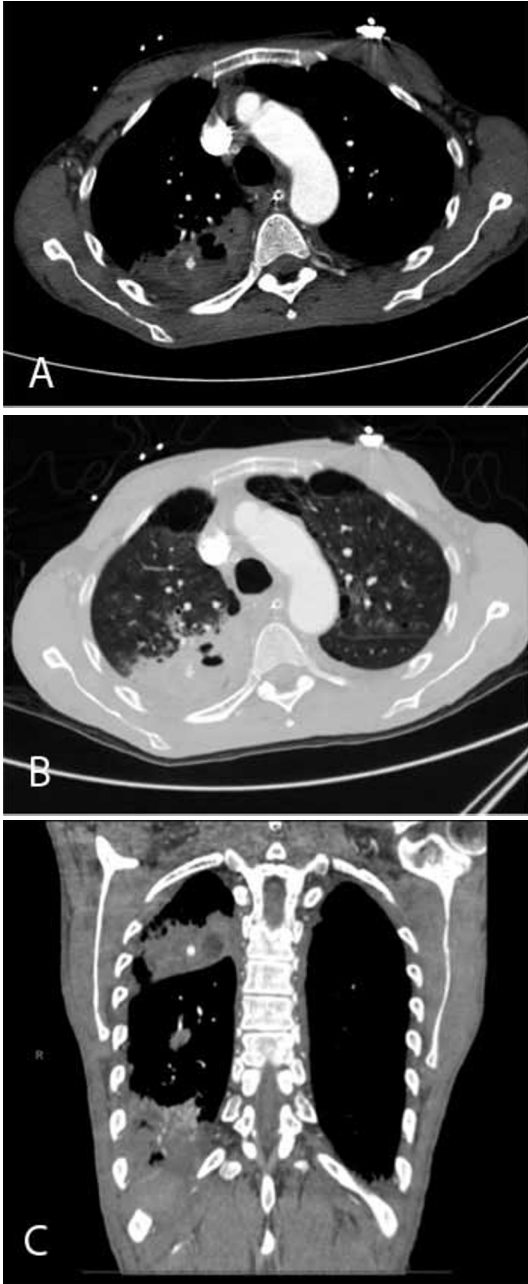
60-year-old African-American male with pulmonary artery pseudoaneurysm. Axial, contrast-enhanced CT image viewed in soft tissue (A) and lung windows (B) demonstrates consolidation of the posterior segment of the right upper lobe with cavity formation and adjacent contrast blush, consistent with active extravasation. (C) Coronal reformatted image.
